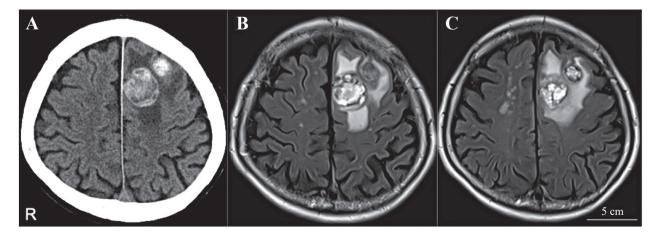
Double hemorrhages in the left frontal lobe. A: Computed tomography (CT) shows two hemorrhages in the left frontal lobe. B, C: Magnetic resonance imaging (MRI) shows two tumors with different intensities and popcorn appearance on fluid-attenuated inversion recovery.
